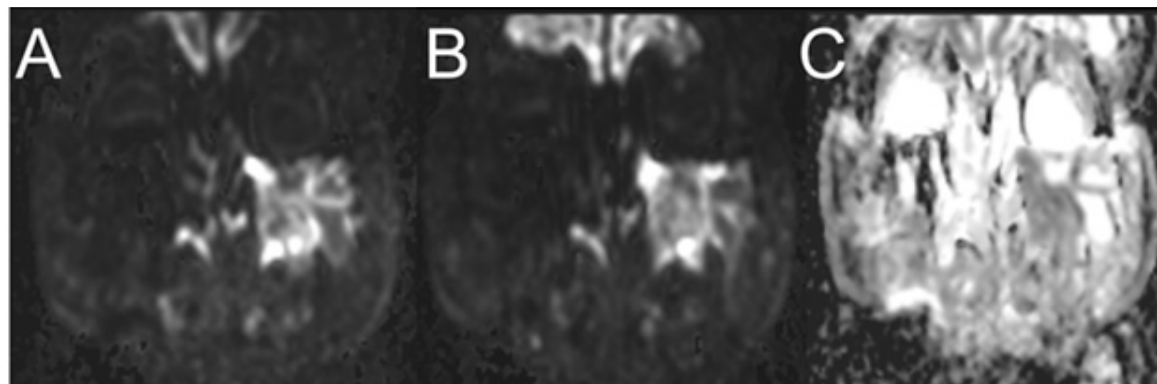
DWI-TRACE ($b=800$) (A-B) / ADC (C) ($b=800$) / (TR: 6300, TE: 68, Slice Thickness: 5mm) coronal slices of the patient demonstrates diffusion restriction (A, B) and lowered ADC values (C).
